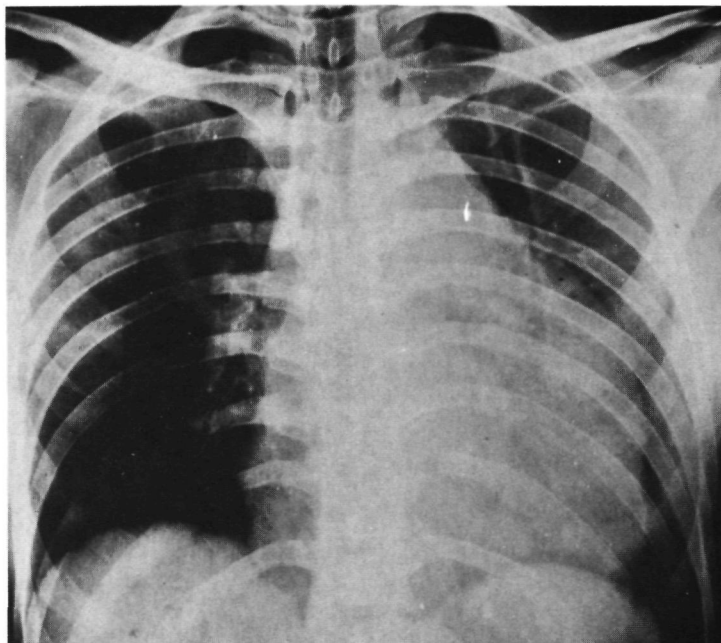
17 Male, 24 years, car passenger, TAR, uneventful recovery. Combination of aortic rupture and cardiac pathology. Chest X-ray: abnormal aortic contour at the level of the aortic knob. Widening of the mediastinum. Normal position of the trachea. Massive enlargement of the cardiac silhouette. Angiography: TAR. At operation hemopericardium due to rupture of the vena cava was found.
